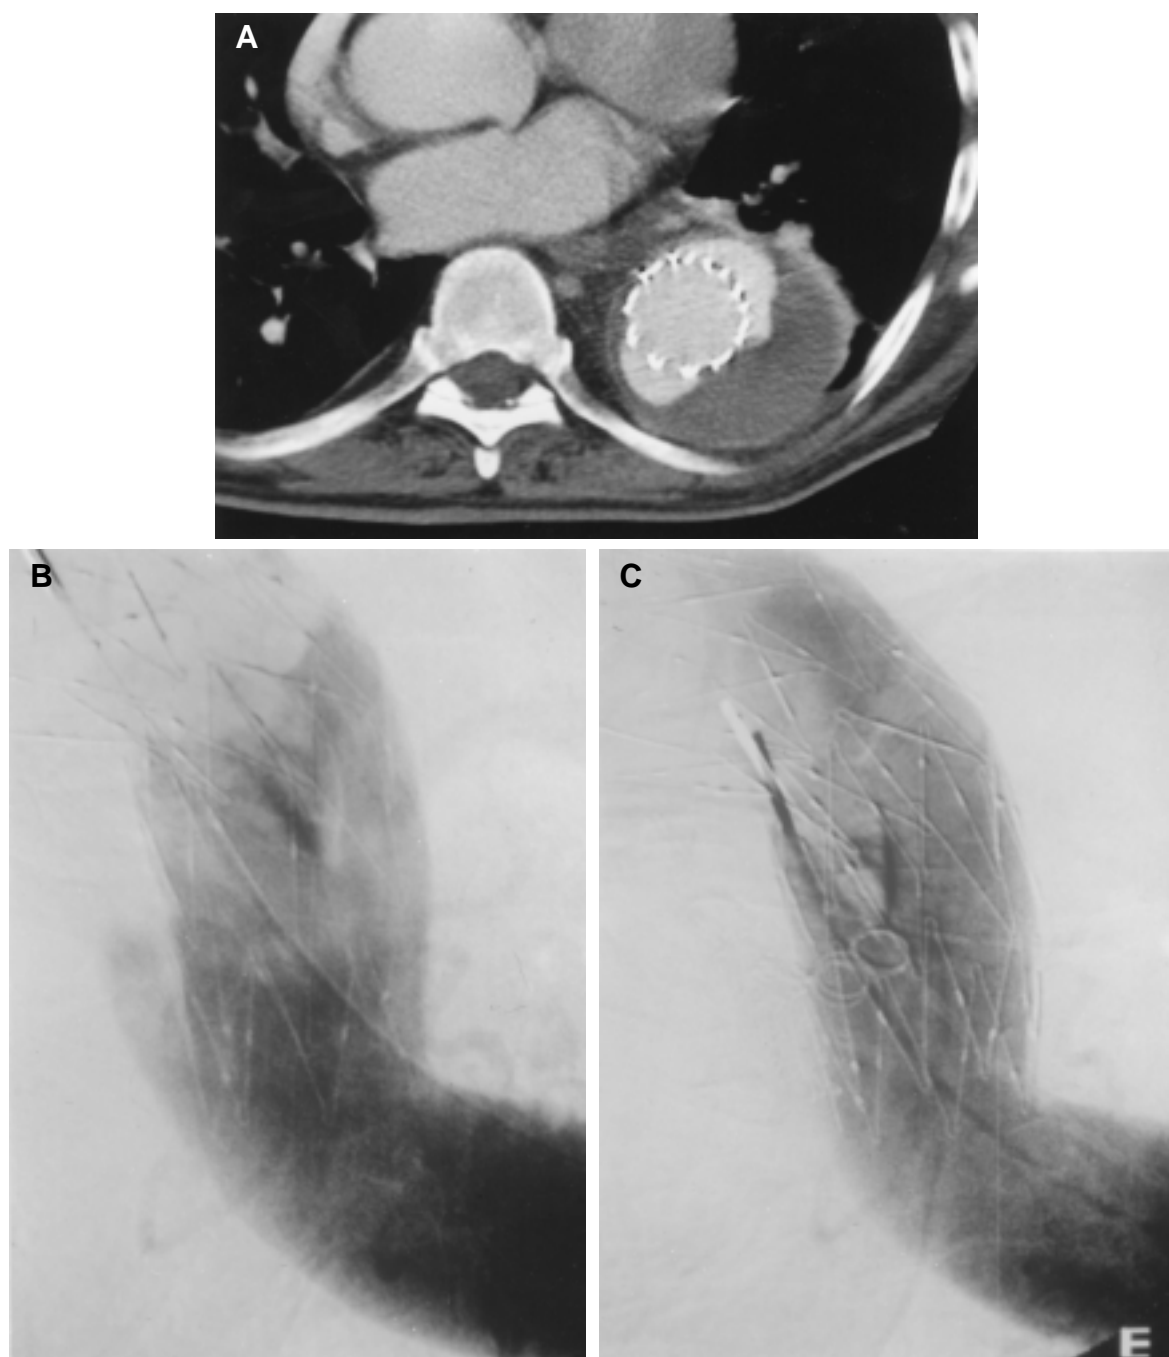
This distal endoleak was detected on the 3-month CT scan (A) and further evaluated with angiography (B). Coil embolization was performed with a radiographic seal of the leak (C). However, although there is no evidence of perigraft flow, it may be possible that the aneurysm would still be exposed to systemic pressures transmitted through the thrombus.
